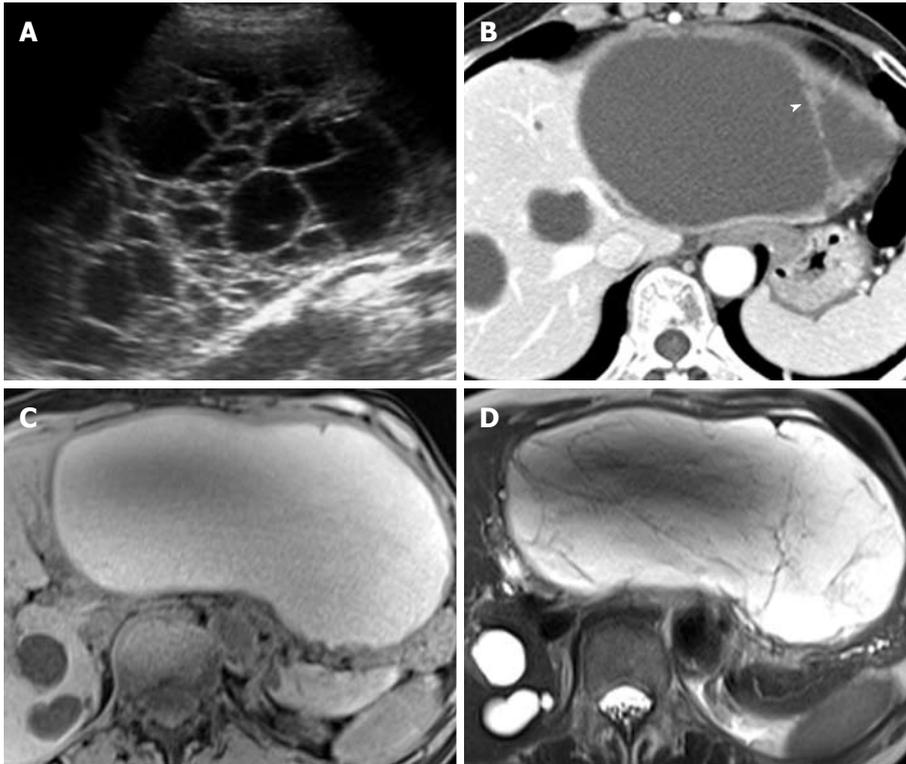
Biliary cystadenoma in the liver of a 55-year-old woman. A: Ultrasound image shows a multiseptated cystic mass in the liver; B: Contrast-enhanced CT image shows a well-circumscribed cystic liver mass, which has similar attenuation to that of hepatic cysts. Note the internal septa with nodular thickening (arrowhead); C, D: T1- (C) and T2-weighted (D) MR images show a multiseptated cystic mass with hyperintensity. CT: Computed tomography; MR: Magnetic resonance.
